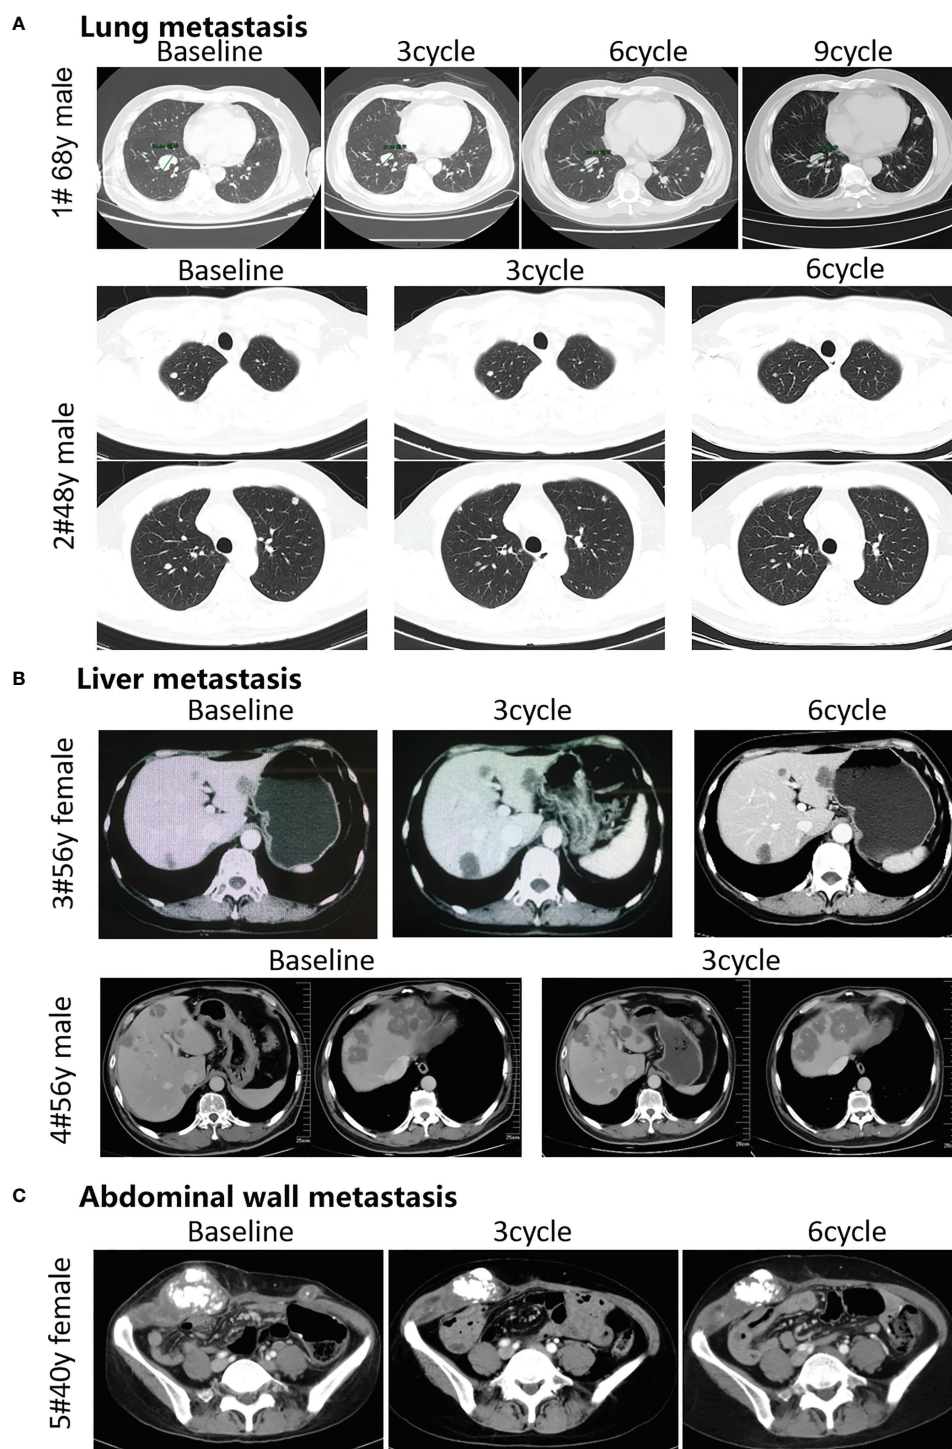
Efficacy of the combination therapy of fruquintinib and anti-PD-1 in patients in MSS mCRC. Radiologic evidence of the 5 patients who achieved PR or SD after the combination treatment. CT scans were performed at the baseline and subsequent treatment cycles. (A) Two CRC patients with lung metastasis: (case 1 # and case 2) were treated with anti-PD-1 and Fruquintinib, and the lesions were significantly reduced (PR). (B) Two CRC patients with liver metastasis: (case 3 and case 4) were treated with anti-PD-1 and fruquintinib, the liver metastases showed stable morphological changes, the density became uniform and reduced, the edge became clear, and the peripheral edge enhancement disappeared. (C) One CRC patient with abdominal wall metastasis (case 5) were treated with anti-PD-1 and fruquintinib, and the lesions were significantly reduced (PR). Individual clinical outcomes and the 5 patients enrolled by therapeutic responses (assessed via RECIST v1.1) in Table 1. No, patient number; y, years old; PR, partial response; SD, stable disease; PD, progressive disease.
